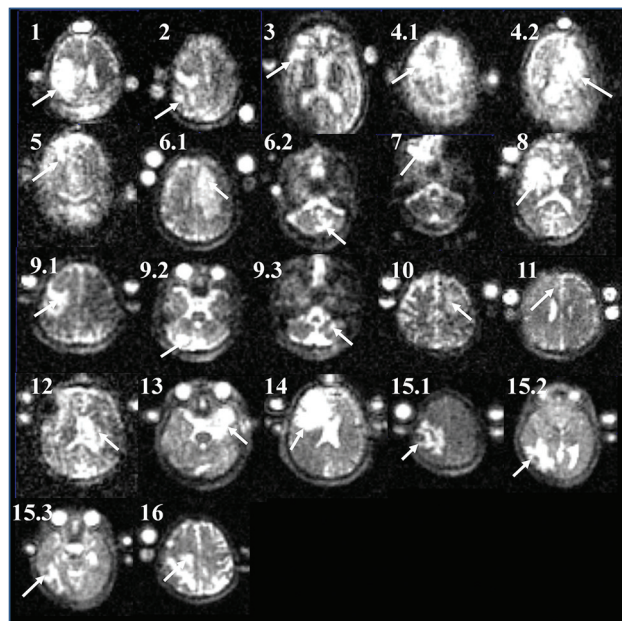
Sodium MR images after B_0 correction of 22 tumors. The arrows pointed to the positions of tumors.
